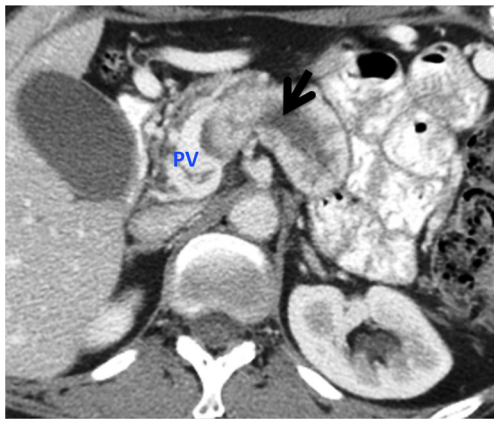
Preoperative CT image from a 54-year-old woman who had received induction chemotherapy for a locally invasive pNET of the pancreatic body. The primary tumor (*arrow*) replaced the body and tail of the pancreas and directly invaded into the portosplenic confluence (*PV*) through the splenic vein
